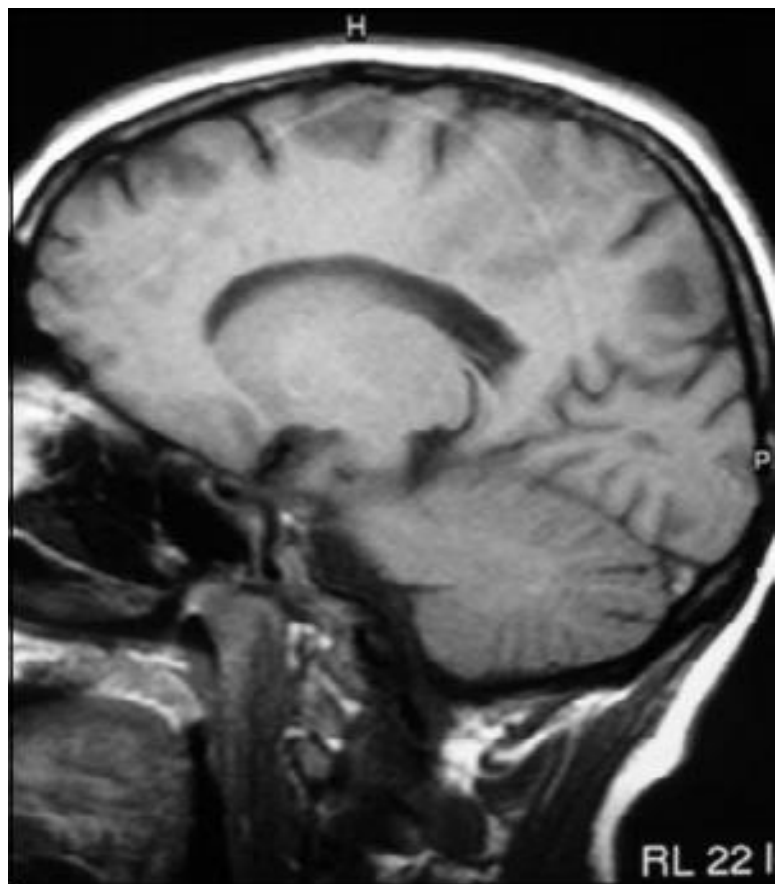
T1-weighted sagittal image with irregular signals in the sagittal sinus.
